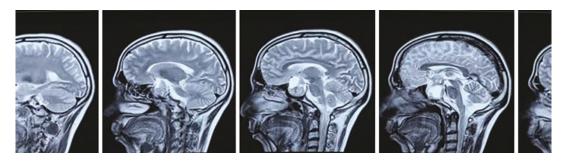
MRI brain sagittal section showing a pituitary tumour with lesion extension into the suprasellar region
